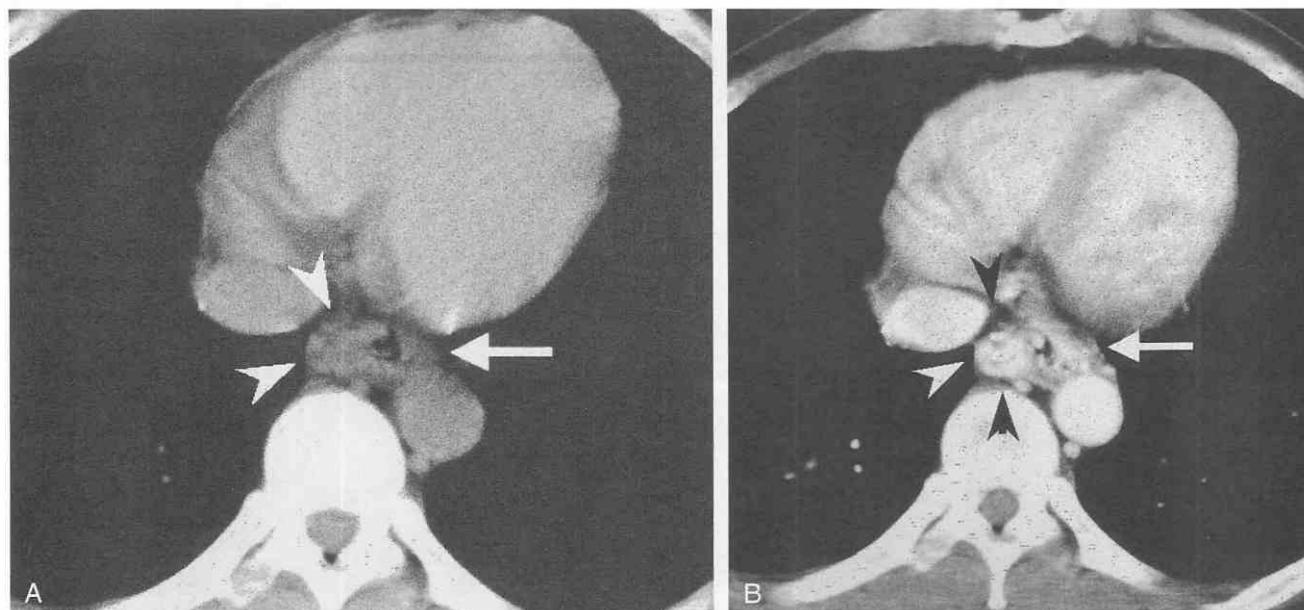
Esophageal and paraesophageal varices. *A*, On this unenhanced CT scan, esophageal wall (arrow) is slightly thickened and nodular lesions (arrowheads) adjacent to the esophageal wall are noted. *B*, After administration of intravenous contrast medium, the esophageal wall (arrow) and multiple nodular lesions (arrowheads) are strongly enhanced.
